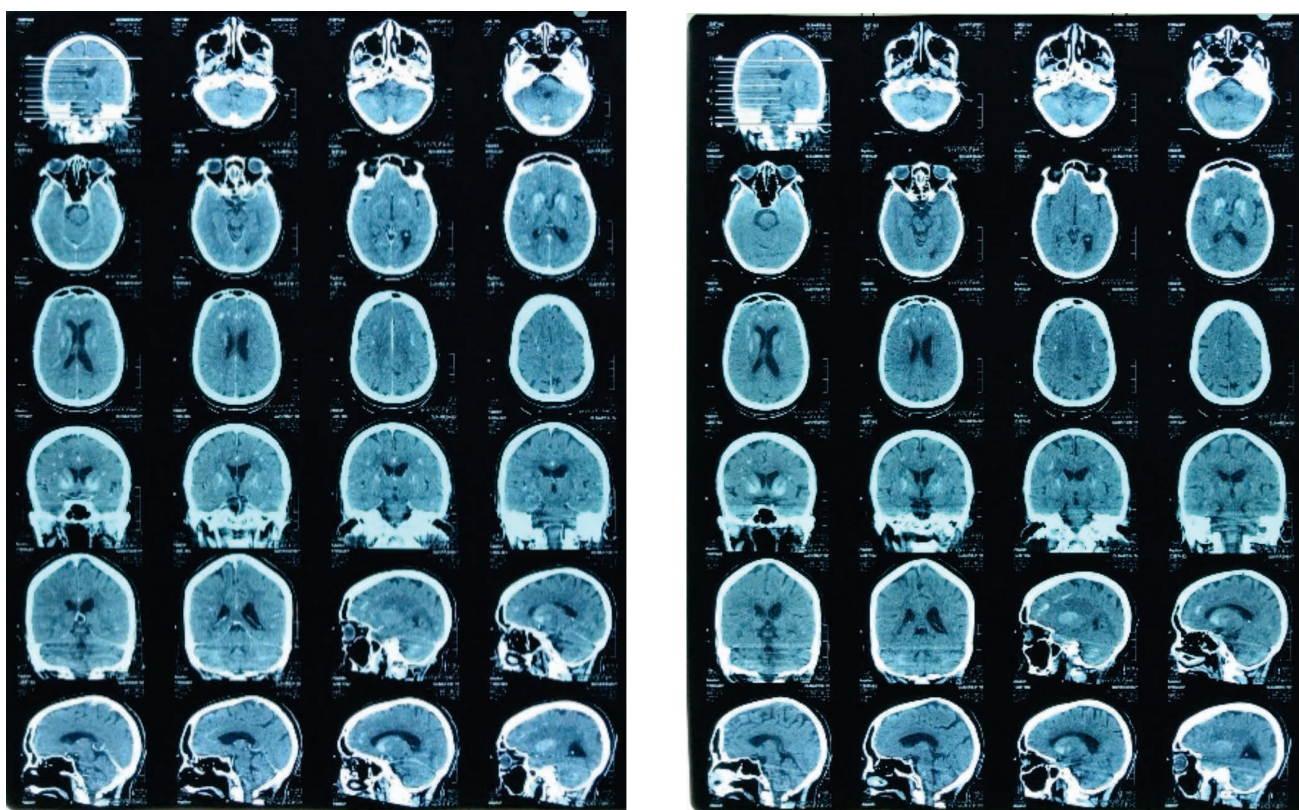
CT-scan of the brain shows multiple intracranial calcifications
